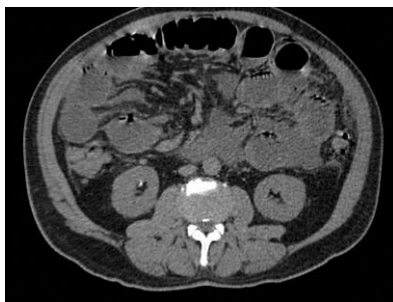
Simple abdominal CT scan, with evidence of small bowel obstruction and a central transition zone in mesogastrium, probably secondary to an internal hernia or adhesions.
